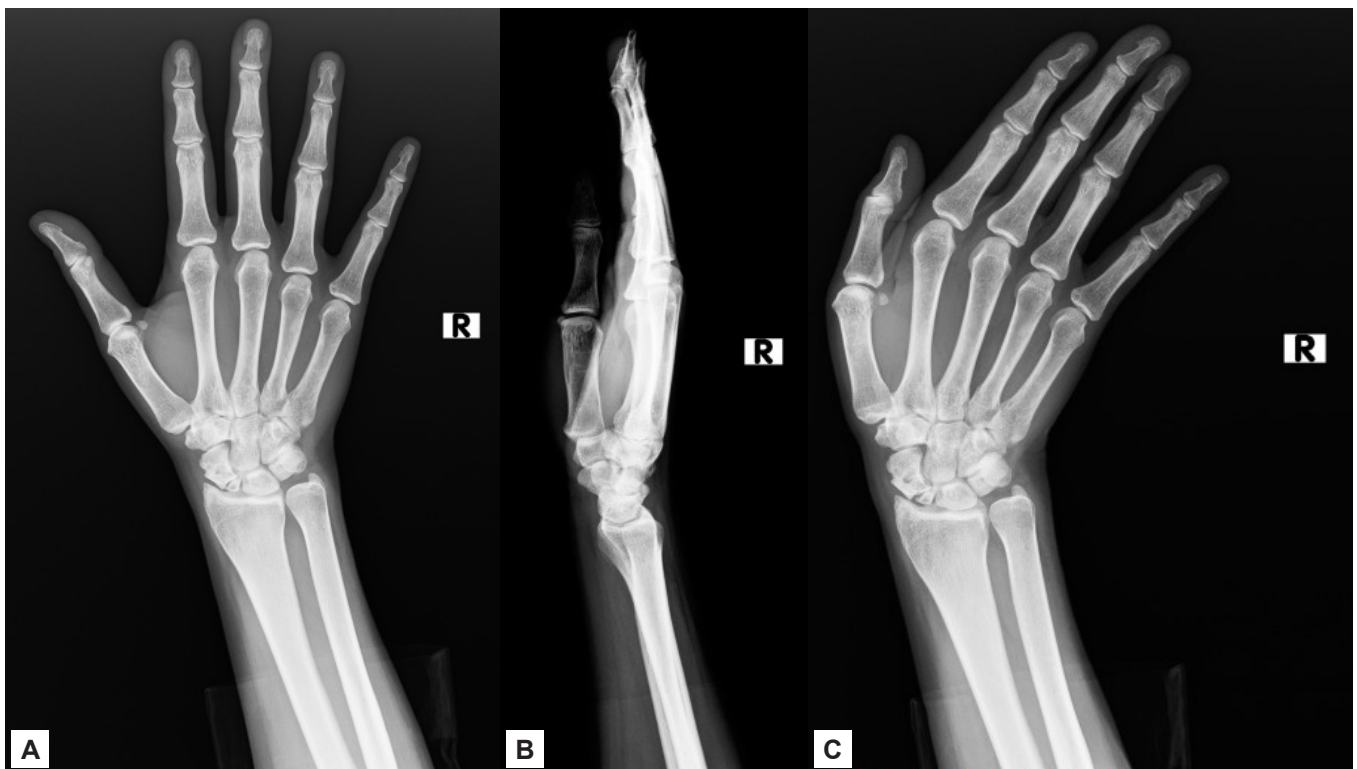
1B,1C. Preoperative X-ray images. H.D, 35 year-old.
